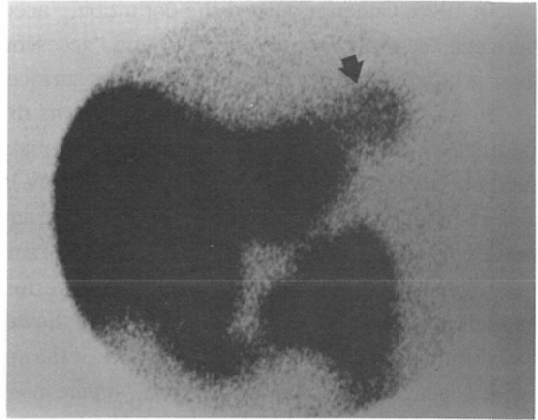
Hepatobiliary scintigraphy (^{99m}Tc -Parabutylinodiacetic acid). Uptake of the accessory lobe of the liver (arrow) corresponded to that of liver scintigraphy (Fig. 2).
